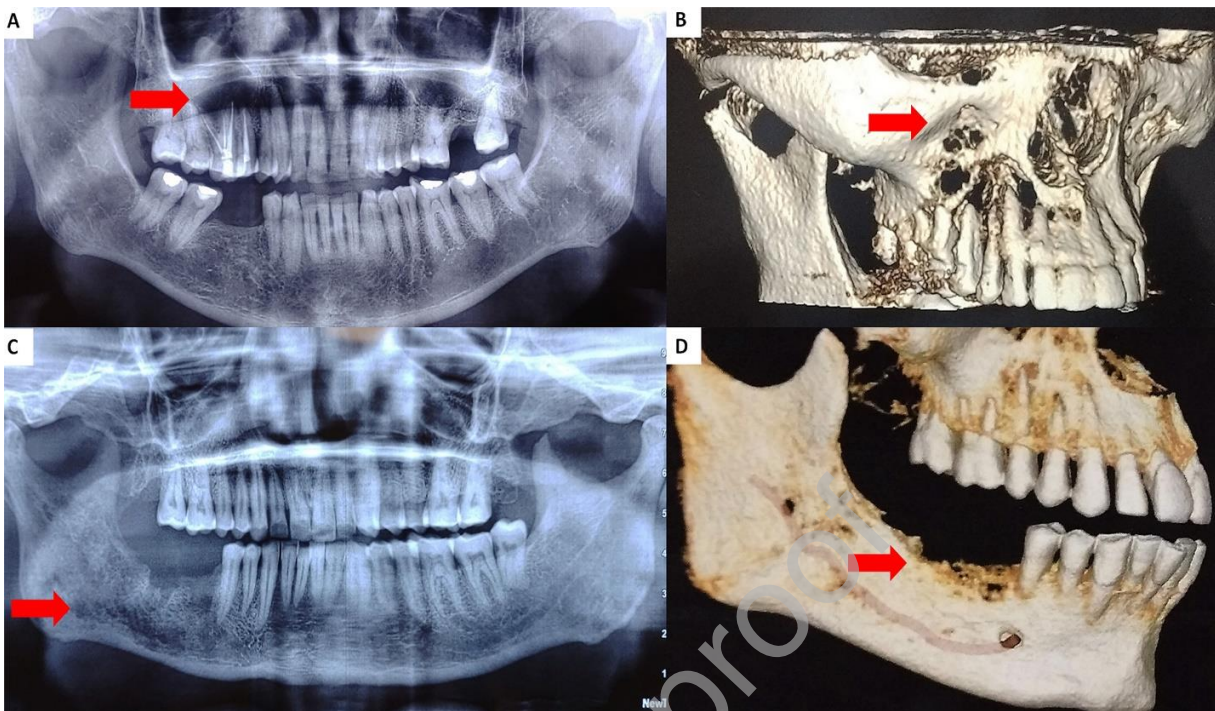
A, B – Radiographs (Case 3) showing osteolytic lesion in the right maxillary posterior region causing break in the medial wall, floor of right maxillary sinus and thinning of nasal floor. C, D – Radiographs (case 4) showed mixed radiolucent- radiopaque osteolytic lesion in the right body-angle-ramus of mandible with ragged and irregular margin giving it a moth-eaten appearance.
